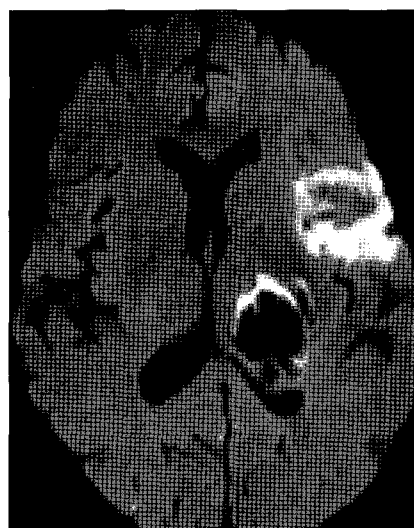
At 5th hospital day, brain diffusion magnetic resonance image showing that there are intracerebral hemorrhage in the left thalamus and acute cerebral infarction in the left middle cerebral artery territory.
